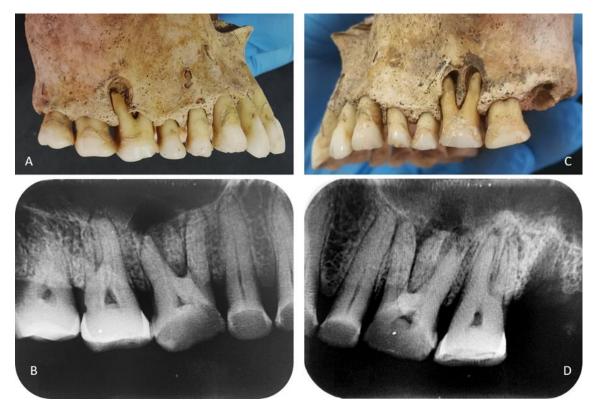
Lateral view of teeth 16 (A) and 26 (C) and the corresponding segmented X-rays of right side (B) and the left side (D). Presence of periapical bone lesions (cysts) and interrupted left and right sinus floor.
